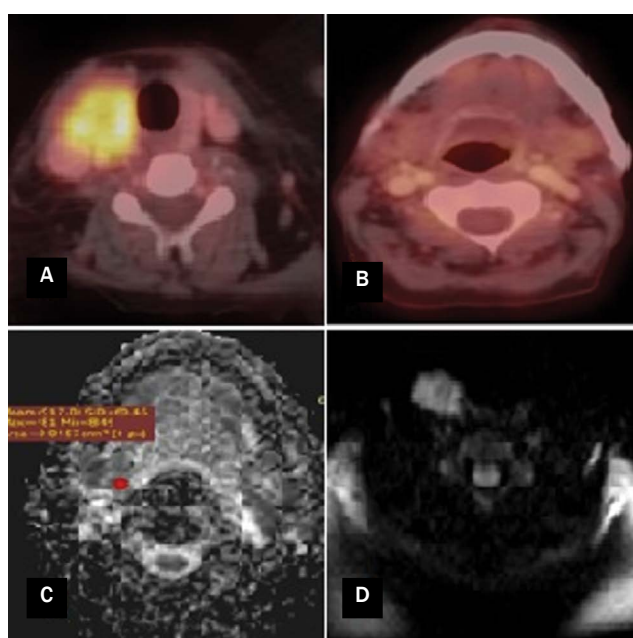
50-year-old woman initially presented with de-novo neck swelling. PET/CT revealed: right thyroid lobe FDG avid focal lesion (A). Non-FDG avid right upper deep cervical nodes (level II; B). MRI showed right thyroid lobe focal nodular lesion, eliciting low T1 and intermediate T2 signal intensities. Clustering Right upper deep cervical lymph nodes (level II) with effaced fatty hilum, some of them are rounded & globular shape with irregular border, eliciting low T1 and intermediate T2 signal intensities. DWI and ADC map revealed Restricted diffusion for the thyroid nodular lesion as well as restricted diffusion and reduced ADC value ($0.9 \times 10^{-3} \text{ mm}^2/\text{s}$) for the nodal lesion (C). The patient underwent surgical interference with total thyroidectomy and right radical neck dissection. Pathology revealed papillary thyroid carcinoma and inflammatory changes of the upper deep cervical lymph nodes
